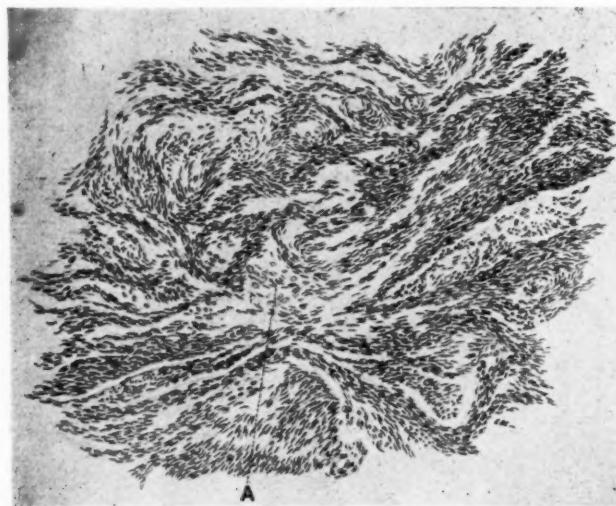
The same uterus was removed three months after the application of about 175 per cent E.S.D. of radium and x-rays. Note the connective tissue formation and the absence of malignant cells.
